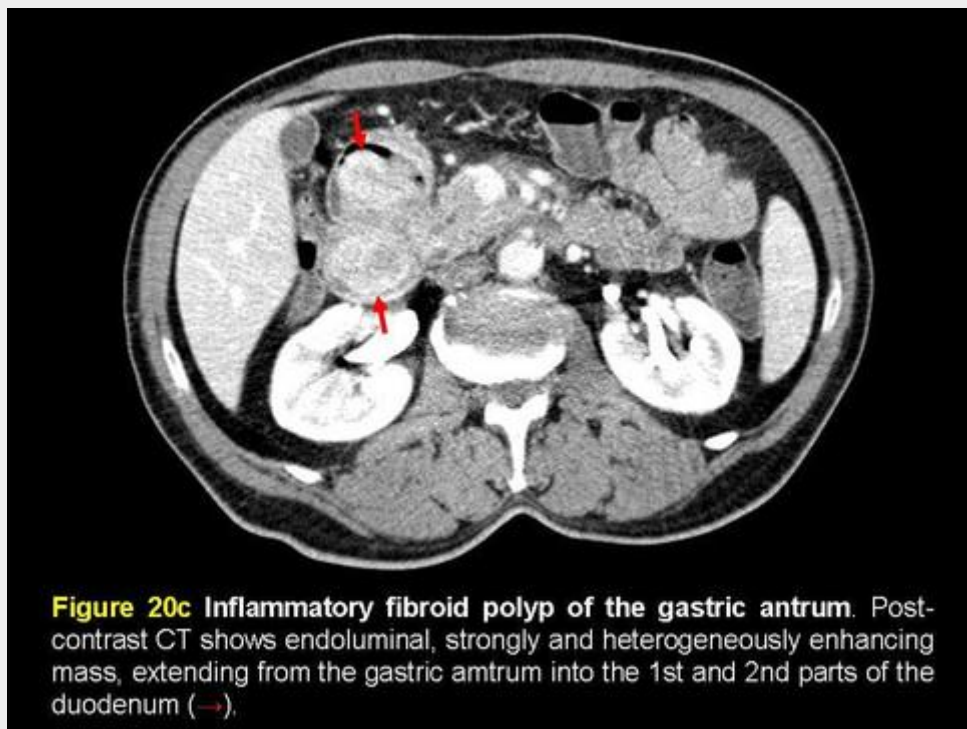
Inflammatory fibroid polyp of the gastric antrum. Post-contrast CT shows endoluminal, strongly and heterogeneously enhancing mass, extending from the gastric antrum into the 1st and 2nd parts of the duodenum (→).
